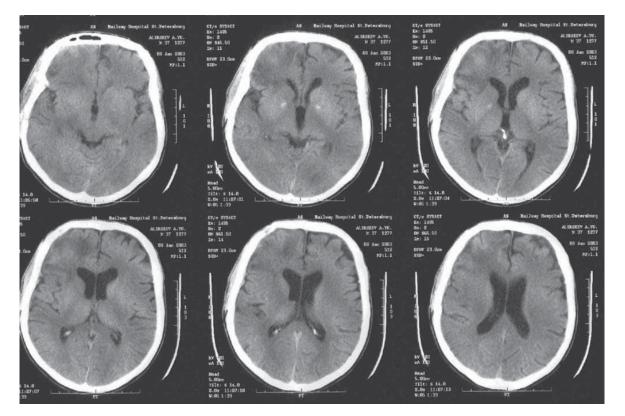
CT scans of a 26-year-old male active duty soldier with mild TBI after exposure to an explosive blast during combat operations. CT performed on 7th day after brain injury.
